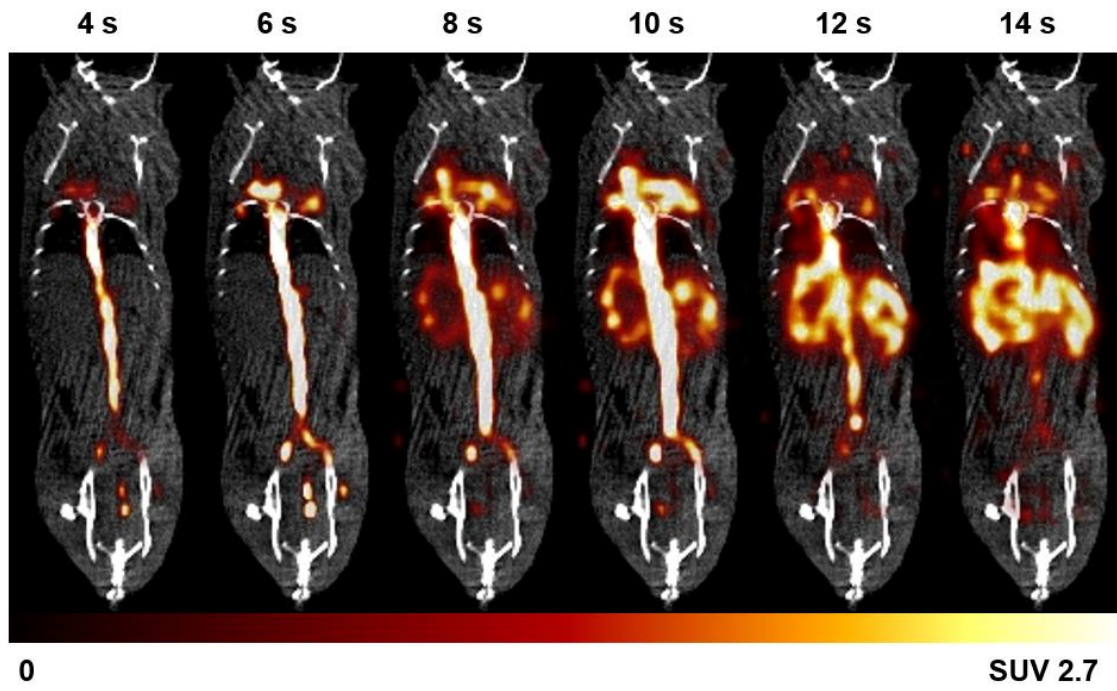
$[^{18}\text{F}]\text{FLT}$ uptake was visualised in the IVC at the beginning of each PET scan. Representative coronal-view PET images of dynamic IVC uptake of $[^{18}\text{F}]\text{FLT}$ from 4 to 14 s post-radiotracer injection. Colour scale bar indicates SUV thresholding to aid visualisation.
